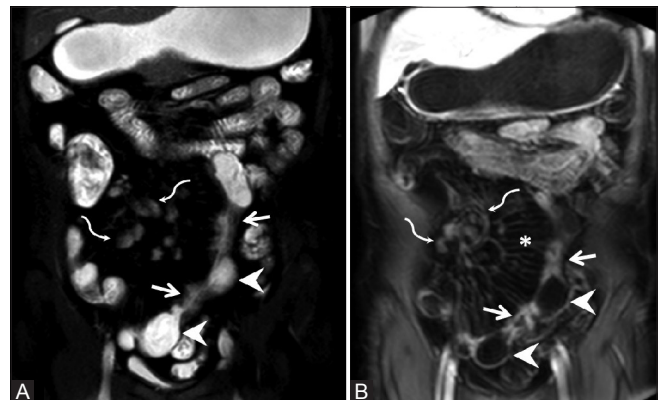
(A and B): Magnetic resonance enterography of classical Crohn's disease. T2-weighted fat saturated coronal MR image (A) and postcontrast coronal T1-weighted fat saturated image (B) showing asymmetric wall thickening of two segments of an ileal loop (straight arrows) with sacculations along antemesenteric border in-between (arrow heads), prominent mesenteric vascularity (asterisk in B), and multiple small mesenteric nodes (curved arrows)
